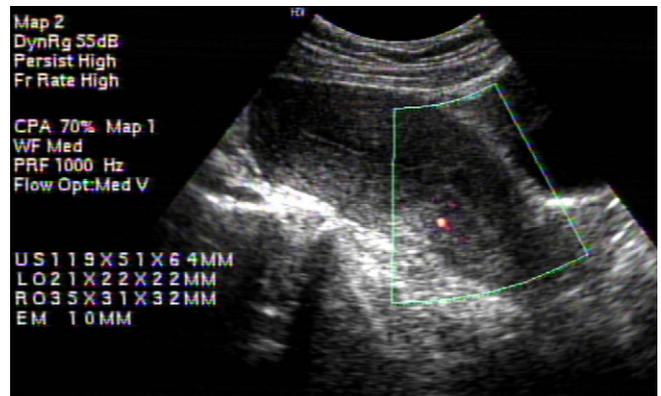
Transvaginal ultrasound reveals no residual material within the uterine cavity.
